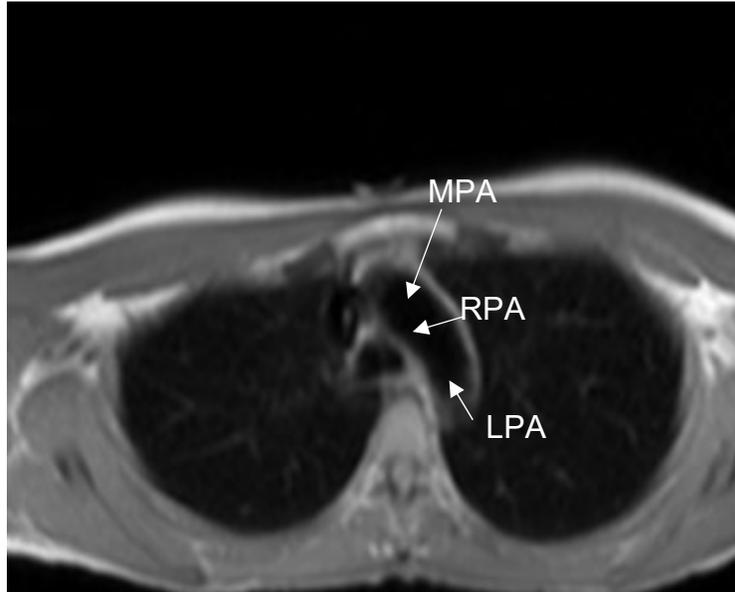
MRI Cross Section Showing main, left, and right pulmonary artery (MPA, LPA, and RPA)
